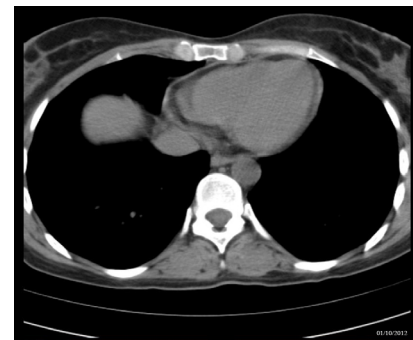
Computed tomography scan performed one week before the ICU admission showing a normal heart.
